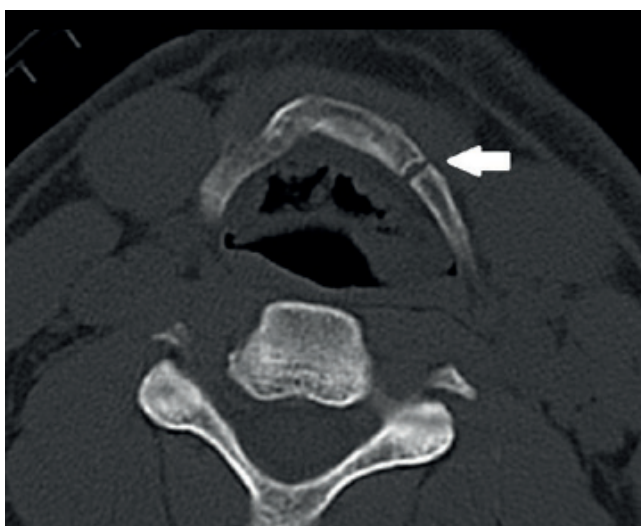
Cervical CT axial section; fracture at the juncture of the hyoid bone left corpus major horn
